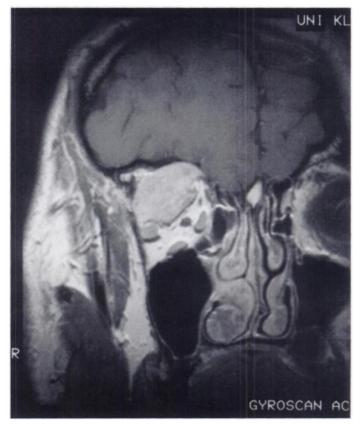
Coronal MRI of head contrasted with gadolinium. Note the expansion in the lateral cranial part of the right orbit measuring 5–2.5 cm in size.
